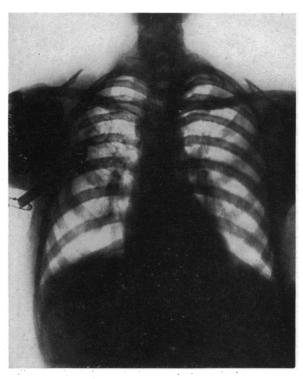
Case I. X-ray taken ten days following drainage of abscess.
